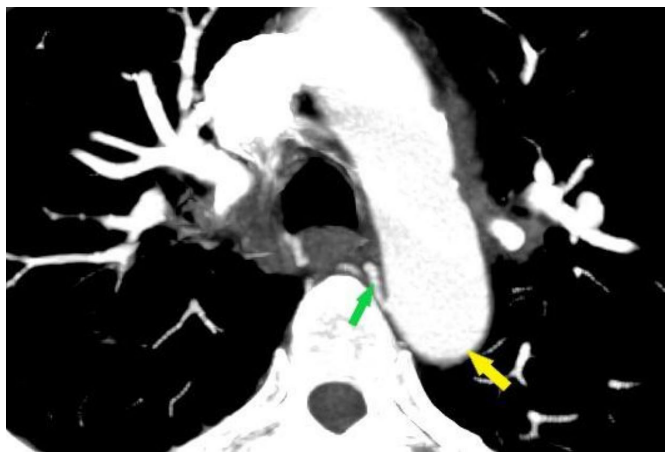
Preprocedural CT aortogram showing the origin of the right bronchial artery (green arrow) from the thoracic aorta (yellow arrow).
